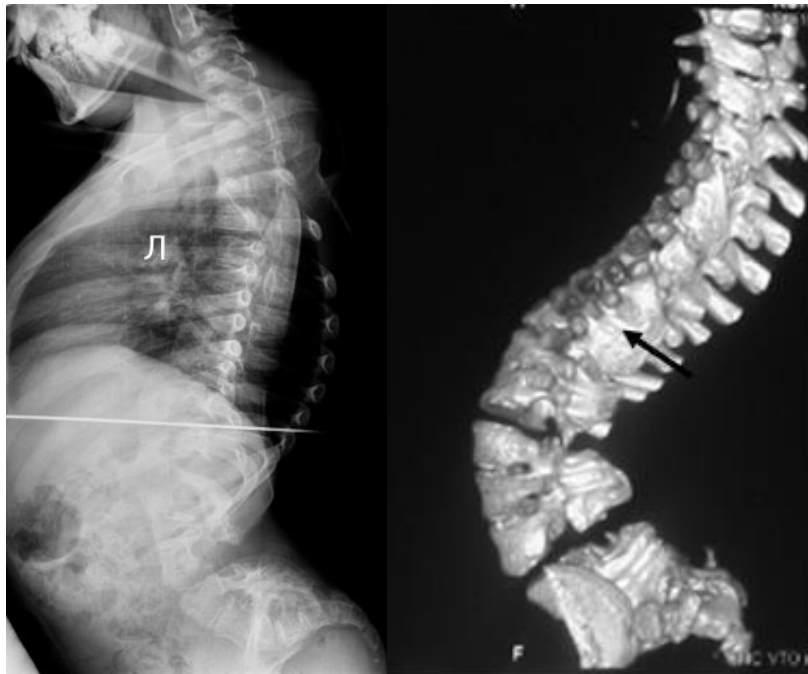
(a,b) Lateral spine radiograph in a-4-year-old-boy with Escobar syndrome showed progressive thoraco-lumbar kyphoscoliosis (figure 6,a). 3D Reconstruction Spine CT scan of a-5-year-old-boy with Escobar syndrome showed severe congenital scoliosis due to non-segmented bar Th11-L5 on the left side (figure 6,b) (arrow).
